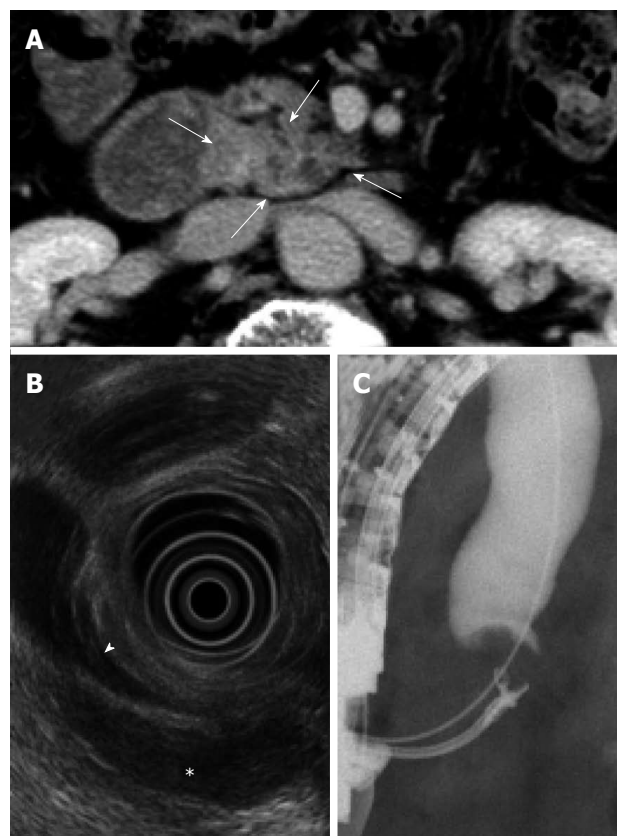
Diagnostic imaging before the second operation. A: Computed tomography showed a low density area at the uncus of the pancreas (arrow); B: Endoscopic ultrasound showed a 3 cm hypoechoic mass (asterisk) at the main pancreatic duct near the common bile duct (arrowhead); C: Endoscopic retrograde cholangiopancreatography showed the presence of inferior common bile duct stenosis.
